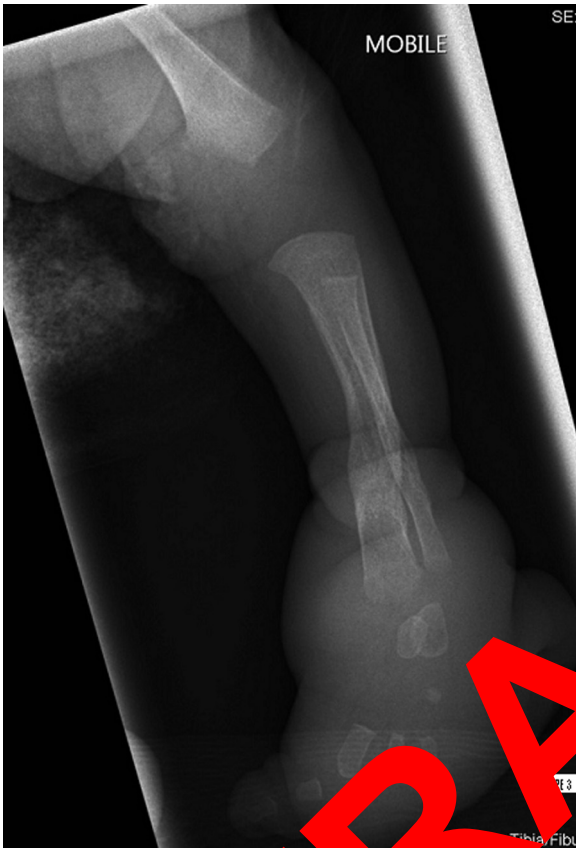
Radiograph showing markedly improved growth of the tibia and fibula with mature new bone formation.
